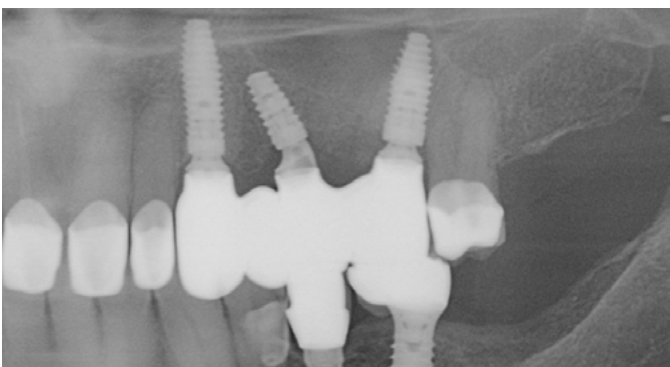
Final radiograph showing stable bone levels and prosthetic fit
